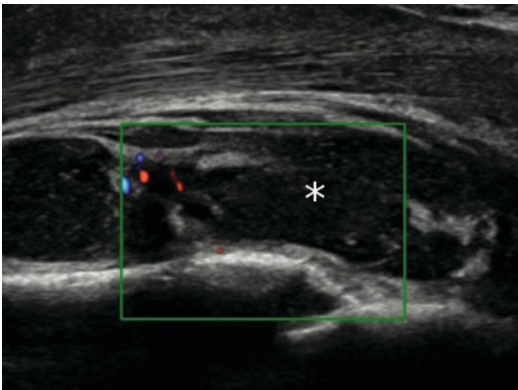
Longitudinal US scan of an anechoic collection with multiple internal echoes (*asterisk*). The margins are well circumscribed and septa are present with color Doppler imaging demonstrating hyperemia at the level of the septum and absence of flow in the center. The abscess is lying on the cortical bony surface of the tibia
